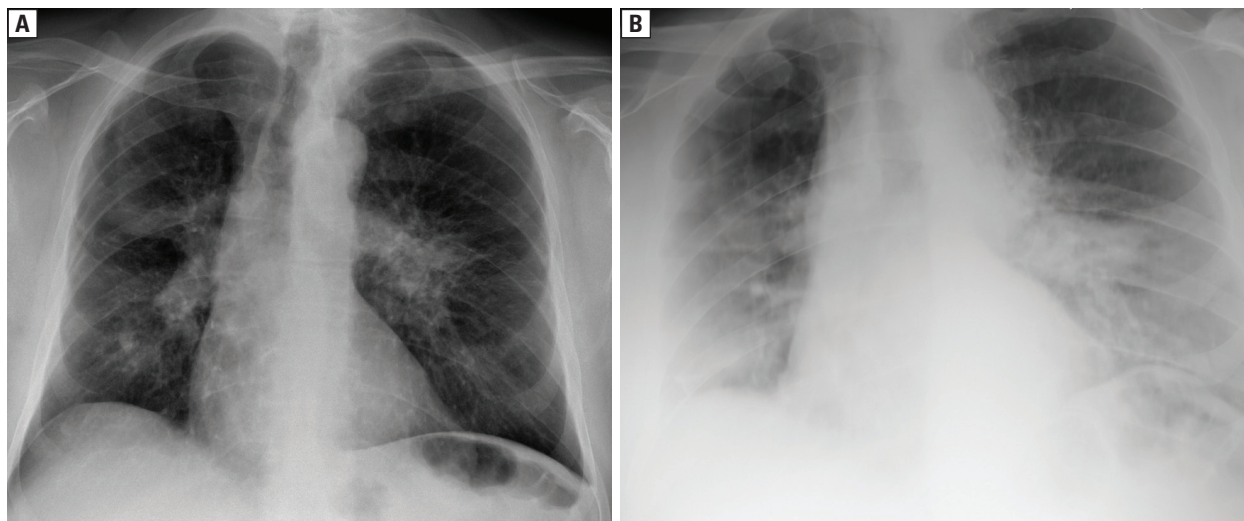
Posterior-anterior chest radiography before SARS-CoV-2 infection. Bilateral, predominantly perihilar and middle zones nodular and patchy parenchymal infiltrates. Symmetrical hilar lymphadenopathy. B. Posterior-anterior chest radiography during SARS-CoV-2 infection. New, bilateral ground-glass consolidations in the middle and lower zones of lungs
